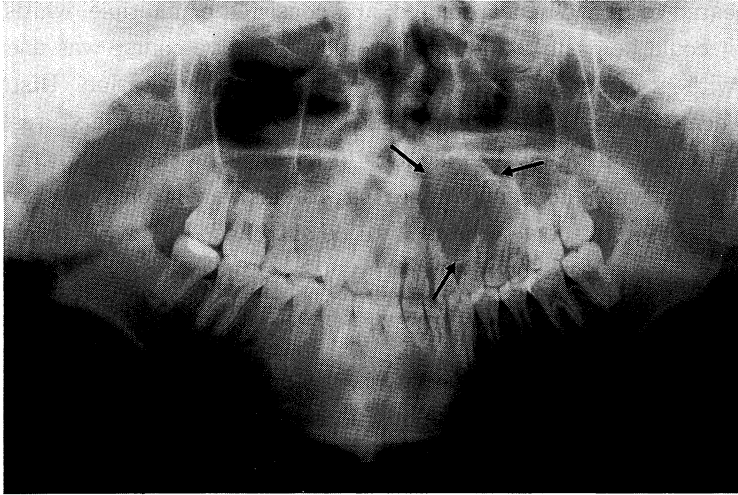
A radiograph demonstrates an ill-defined radiolucency involving the alveolar bone between the roots of the left upper lateral central incisor and second premolar (arrows).
